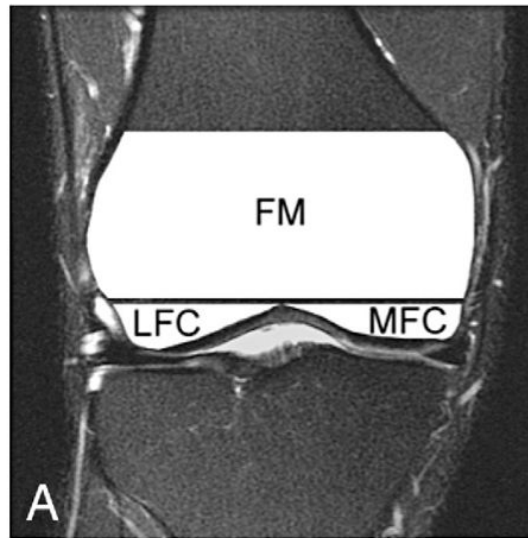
(A) A graphical representation of the segmented bone compartments (FM, LFC and MFC are shown) from a coronal MR image. A typical axial Fiesta-c image acquired at 7 T from a healthy volunteer with segmented LFC, MFC (B) and FM (C) is shown.
